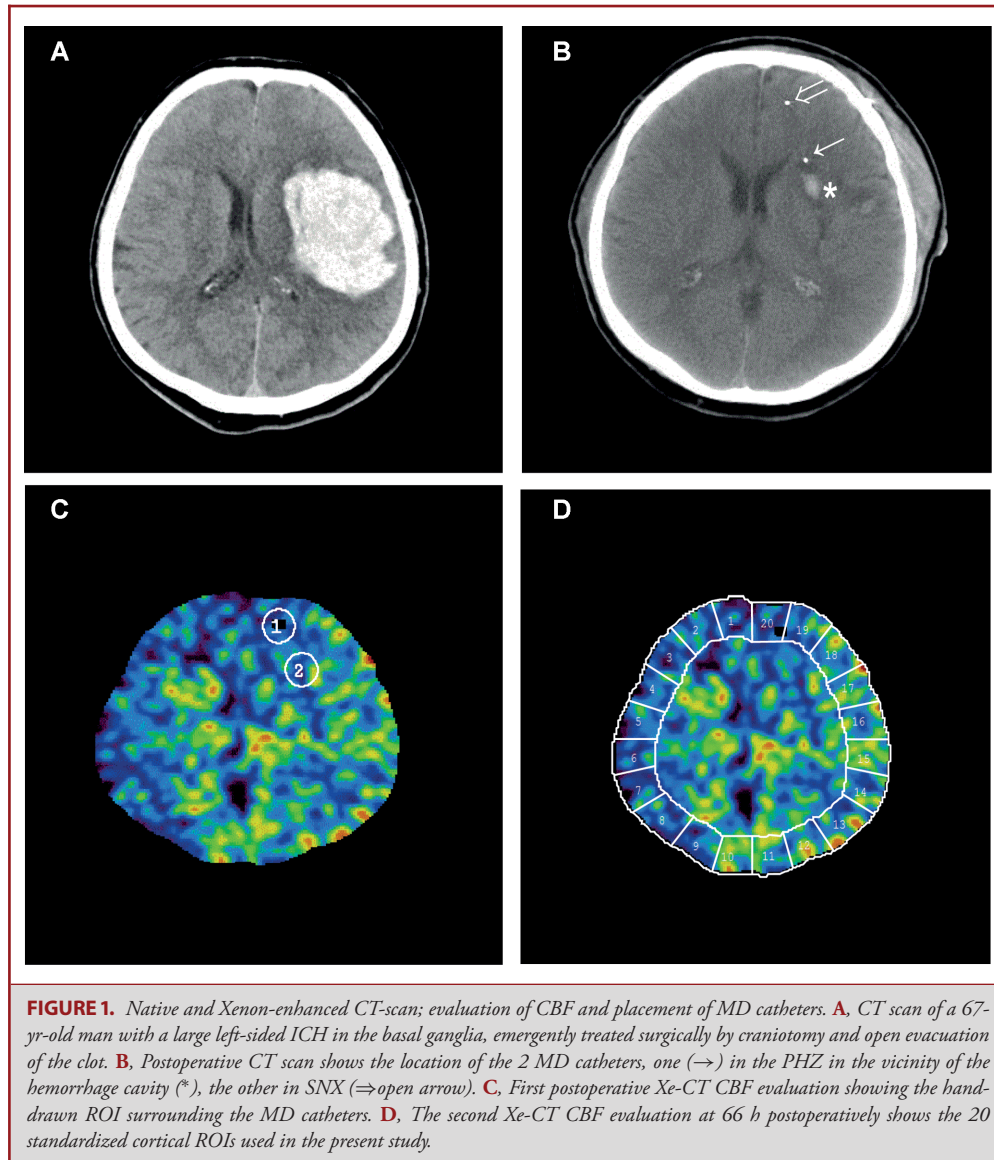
Native and Xenon-enhanced CT-scan; evaluation of CBF and placement of MD catheters. A. CT scan of a 67-yr-old man with a large left-sided ICH in the basal ganglia, emergently treated surgically by craniotomy and open evacuation of the clot. B. Postoperative CT scan shows the location of the 2 MD catheters, one (\rightarrow) in the PHZ in the vicinity of the hemorrhage cavity (*), the other in SNX (\Rightarrow open arrow). C. First postoperative Xe-CT CBF evaluation showing the hand-drawn ROI surrounding the MD catheters. D. The second Xe-CT CBF evaluation at 66 h postoperatively shows the 20 standardized cortical ROIs used in the present study.
